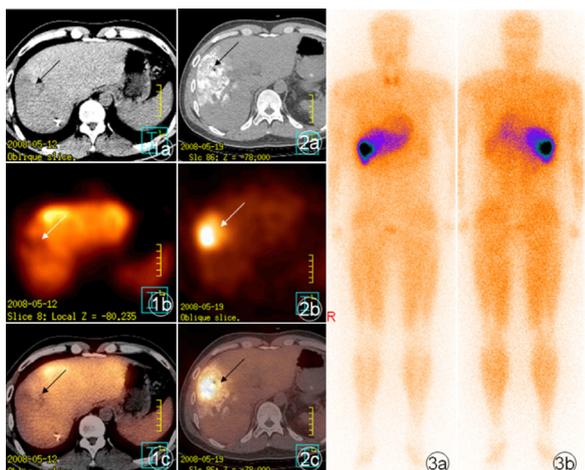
A male HCC Patient Aged 40 years. 1 ^{99m}Tc -PHY hepatic colloid SPECT/CT tomographic image showed right hepatic lobe carcinoma (1c integrated hepatic tomographic image as indicated by arrow head); 2 SPECT/CT hepatic tomographic image at Day 5 post-therapy showed there was an excellent deposit of lipiodol in right hepatic lobe tumor regions and radioactivity concentration predominantly in lesions (2c integrated image as indicated by arrow head); 3 Systemic SPECT imaging (a: anterior and b: posterior) at Day 5 post-therapy showed that radioactivity was predominantly concentrated in hepatic and right hepatic lobe tumor regions. And there was a small amount of radioactive concentration in thyroid
